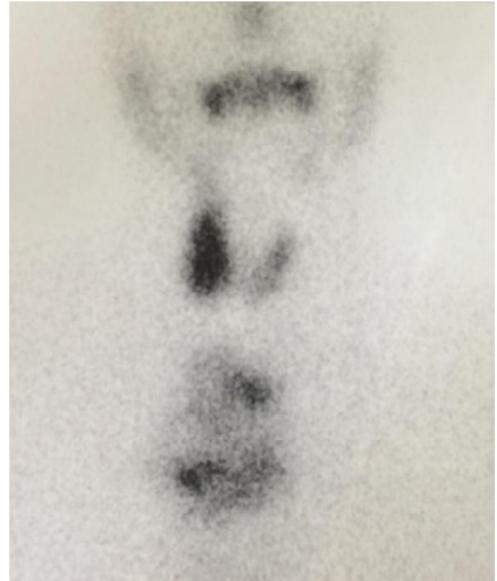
Tc-99m pertechnetate thyroid scintigraphy by a parallel hole collimator. Increased nonhomogeneous radiotracer uptake on the right thyroid lobe (due to nodular hyperplasia) and the mass lesion located in the mediastinum. Note that the mediastinal activity uptake is not in continuity with the thyroid gland.
